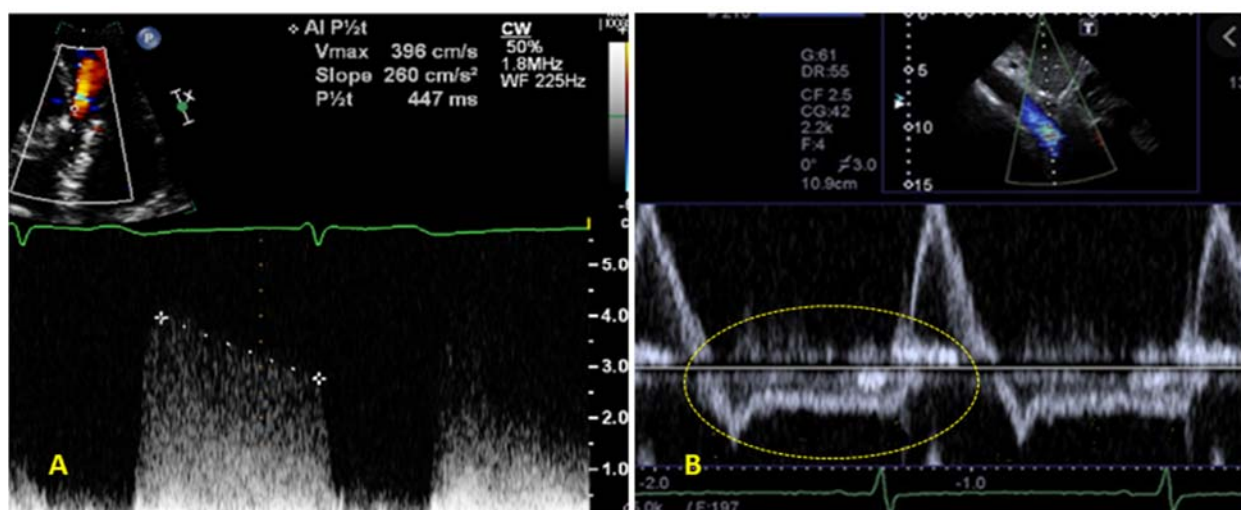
(A) CW Doppler spectral recording of AR regurgitant signal and measurement of pressure half-time; (B) PW Doppler spectral recording from abdominal aorta showing flow reversal.
